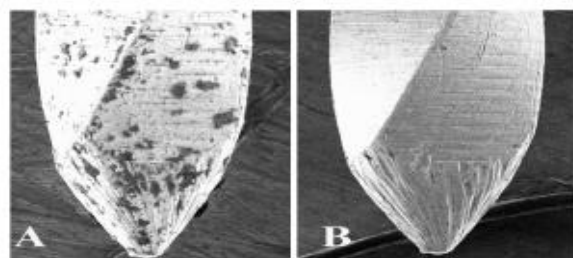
Hand instruments, (A) before cleaning and (B) after ultrasonic cleaning ($\times 150$)
